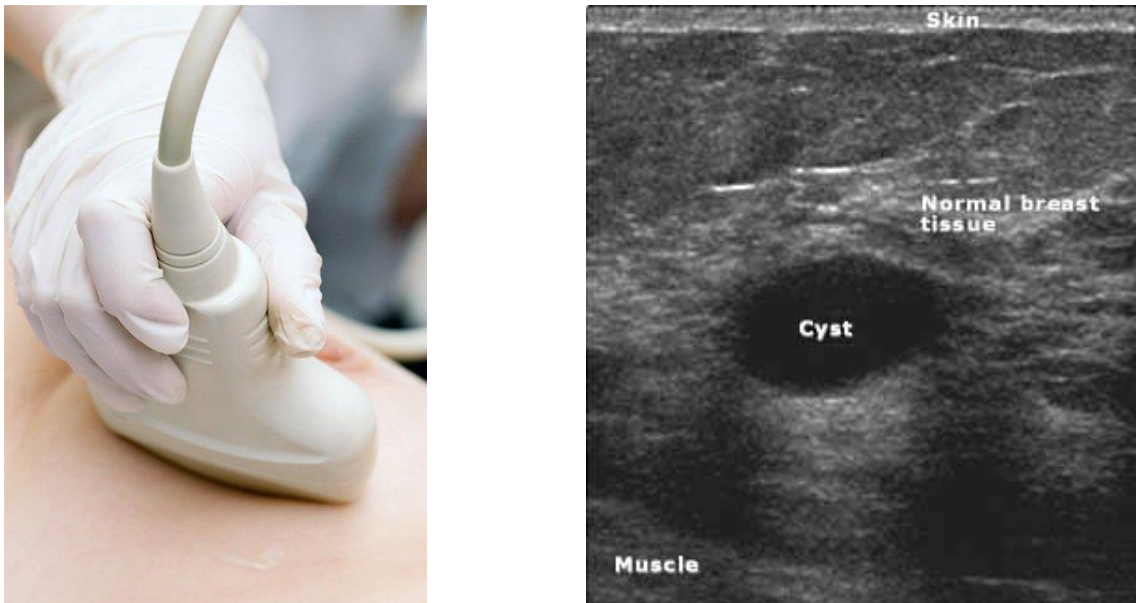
Ultrasonic Breast Imaging (left) (BHI Houston, 2020) and Output Image (right). The scanner contacts a small area of the breast and images a 2D 'slice' of the breast using phased array ultrasound, where the y axis of the output image represents depth into the breast. Pressure is light and friction is reduced with coupling gel.
